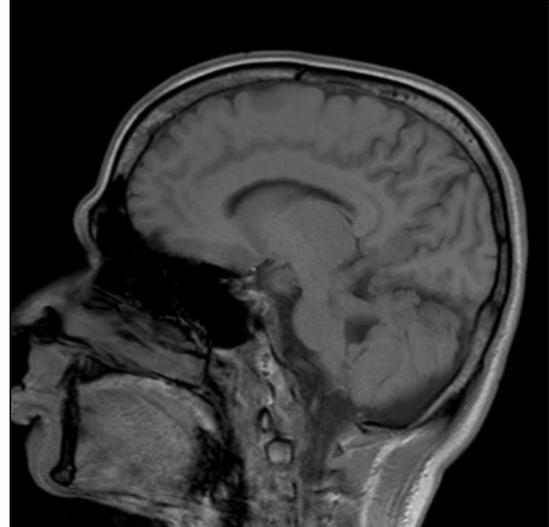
Parasagittal T1-weighted image shows thickened, elongated and horizontally orientated superior cerebellar peduncles.
